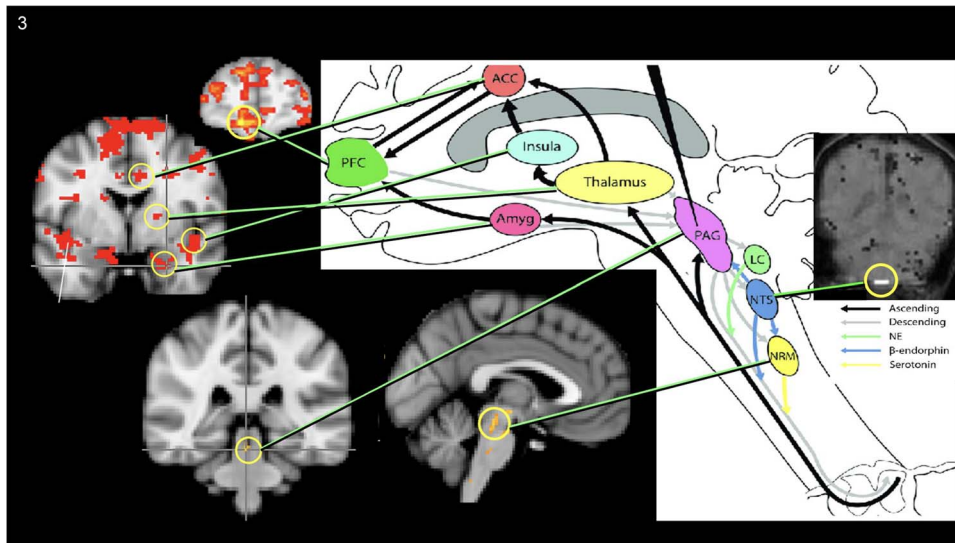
The right side represents the brain regions classically activated by painful stimulation. The left side represents the brain regions activated by orgasm as determined by functional magnetic resonance imaging, at least in women. The brain regions shared between orgasm and pain include the medial prefrontal cortex, insula, amygdala, periaqueductal gray, and nucleus accumbens. Of note, each of those regions contains inhibitory neurotransmitters, which could provide the neurotransmitter basis for the inhibition of pain by orgasm and, reciprocally, inhibition of orgasm by pain.
